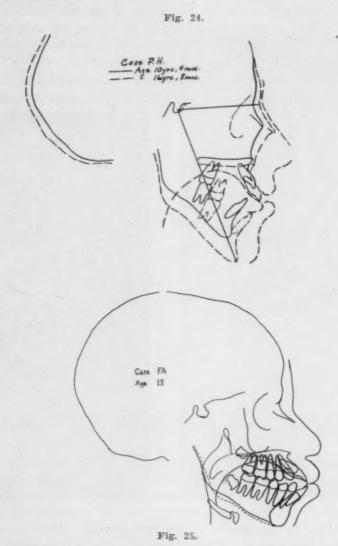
Superimposed tracings of cephalometric x-rays made on patient with abnormally large tongue.
